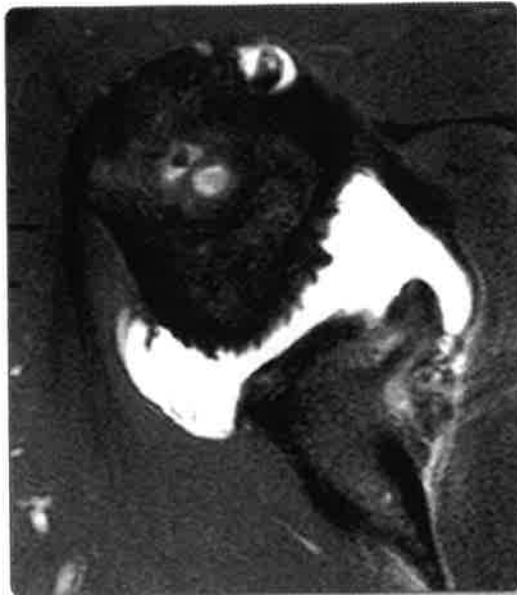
Arthro-MRI in shoulder instability.
